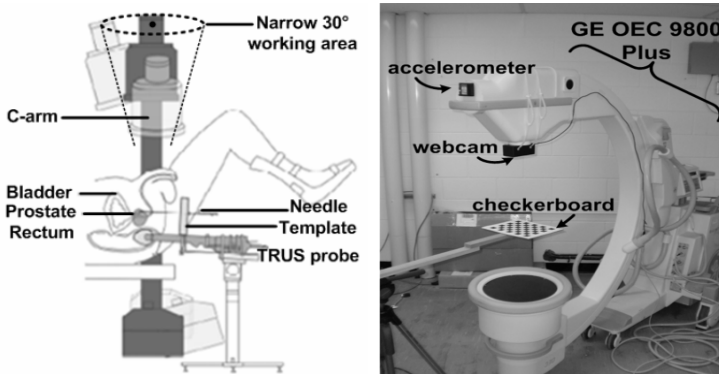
(*Left*) Typical ultrasound guided brachytherapy setup with a C-arm operating in a narrow range. (*Right*) Full scale experimental setup with the accelerometer mounted on top and the webcam underneath the X-ray source. More details of devices can be found in [1].
